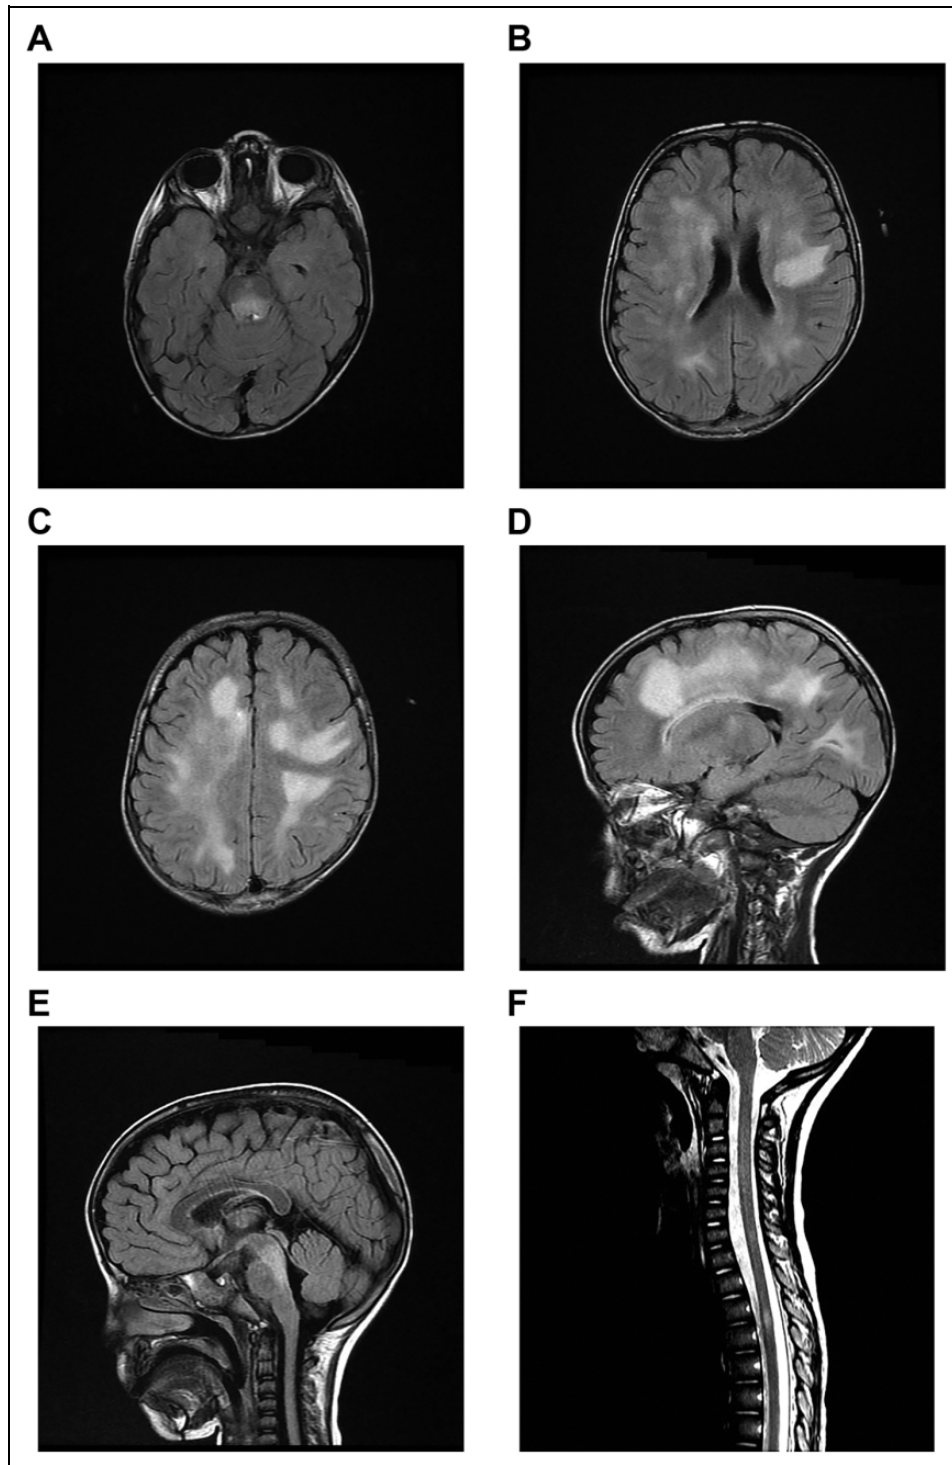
MRI Brain and Spine. (A) Axial FLAIR sequence showing hyper intensity in the posterior aspect of the pons. (B) And (C) Axial FLAIR sequences showing confluent bilateral non-enhancing deep and sub-cortical white matter hyper intensities seen in the frontal and parietal lobes. (D) Sagittal FLAIR sequence showing confluent periventricular and subcortical white matter hyper intensity seen in the frontal and parietal lobes. (E) Sagittal FLAIR sequence showing hyper intensity in the posterior aspect of the pons. (F) Sagittal T2 sequence of MRI spine showing hyper intensity at the level of T3 and T4 vertebrae.
